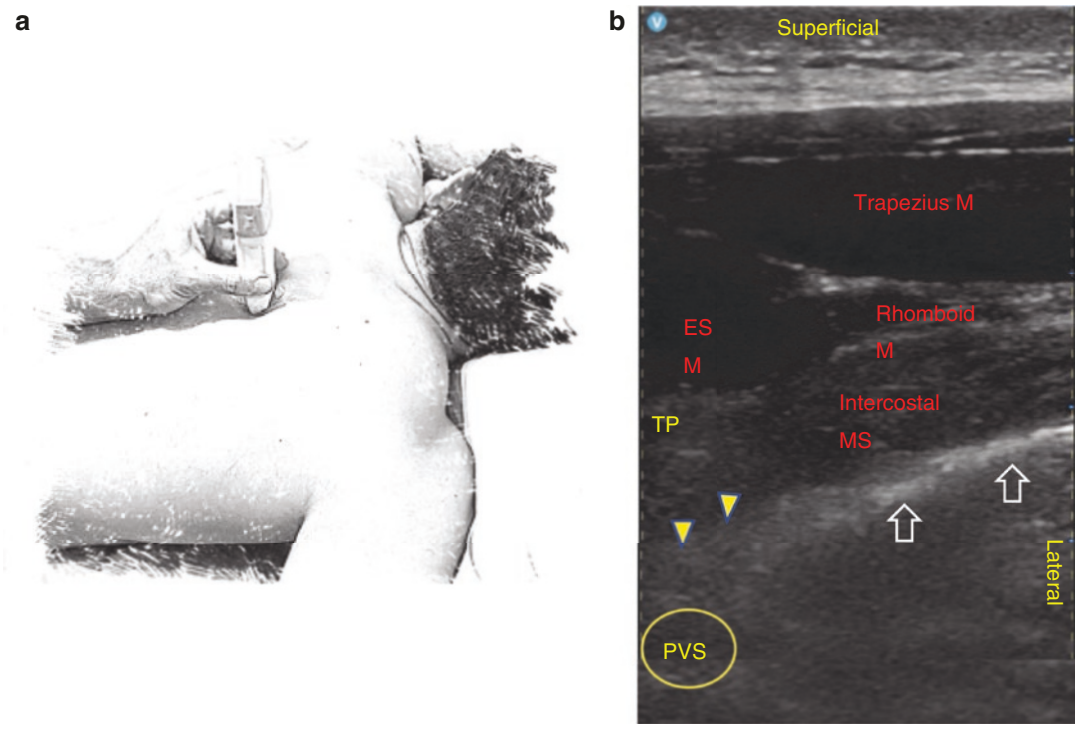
Ultrasound-guided Paravertebral Block (PVB). (a) Position of the ultrasound probe to achieve the transverse approach to the paravertebral space (PVS). Blue dot is the location of the needle approach. (b) Ultrasonographic
